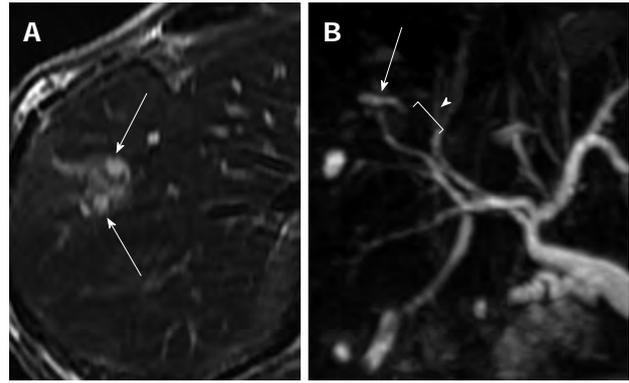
Magnetic resonance imaging. A: The T2-weighted magnetic resonance imaging shows a hyperintense lesion along the dilated intrahepatic duct (arrows); B: Magnetic resonance cholangiopancreatography shows a stricture of biliary duct (arrow) with the upstream dilatation (arrowhead).
